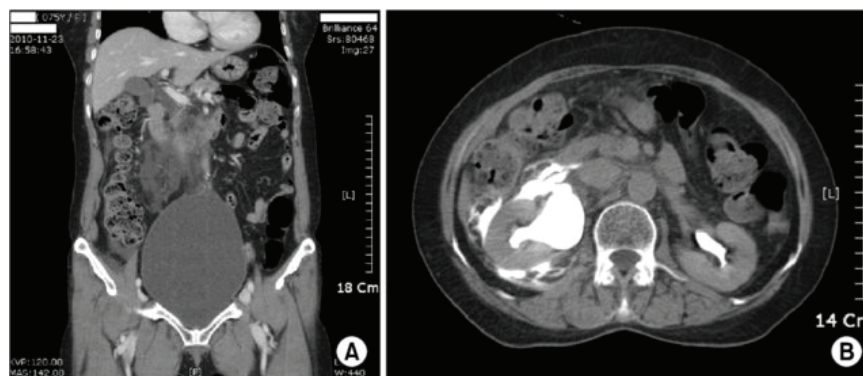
CT image showing a dilated bladder, suggestive of urinary retention. (B) CT image showing extravasation of radiopaque contrast from the ruptured ureter. Contrast medium leakage into the perirenal space is shown. CT, computed tomographic.
